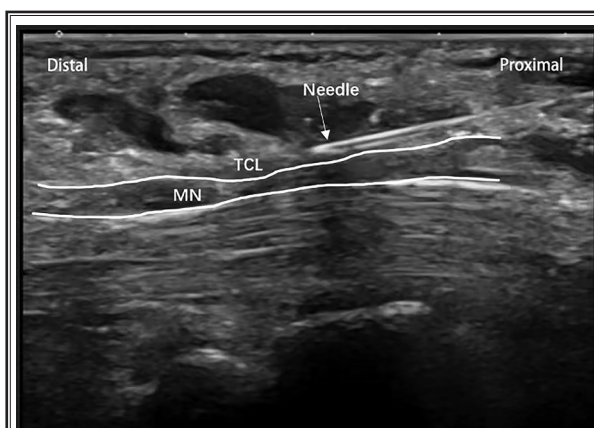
Ultrasound-guided TCL needle release via long-axis approach.*
